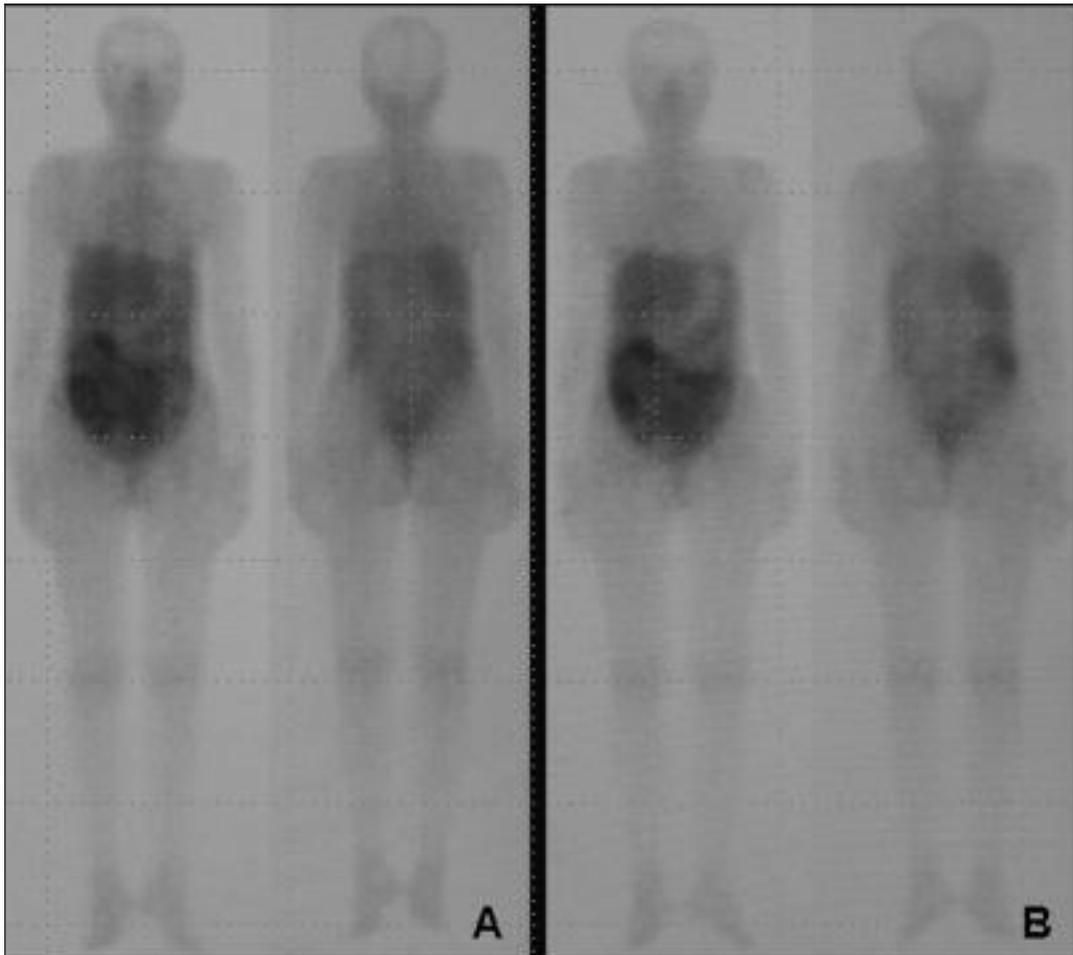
Gallium-67 whole-body scintigram taken at 24 hr (A) and 48 hr (B) after injection shows diffuse and intense uptake in the abdomen.
